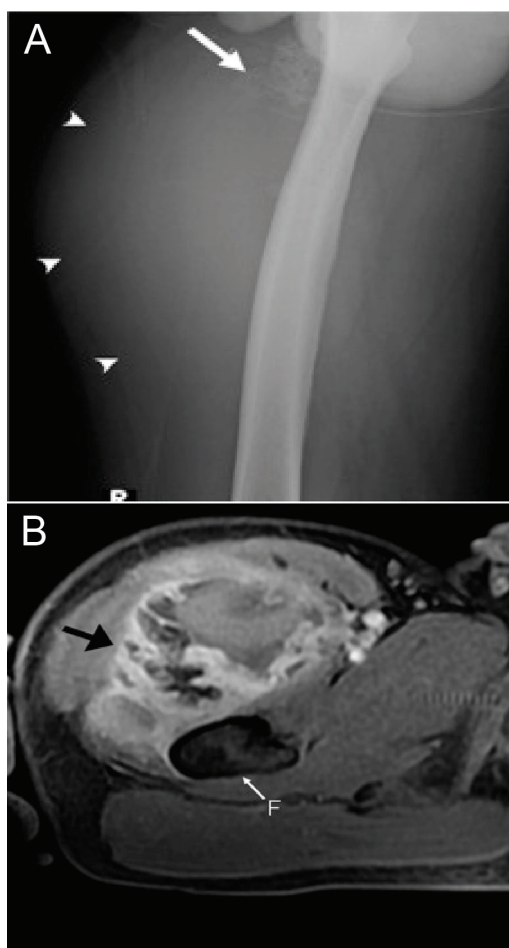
(A) The radiograph of the right thigh shows a soft tissue mass (arrow head) containing calcification (arrow). (B) Axial post intravenous gadolinium MRI reveals a heterogenous mass in the quadriceps muscle without continuity with the bone. Note the dark area in the mass (black arrow) corresponding with calcification (F = femur).
